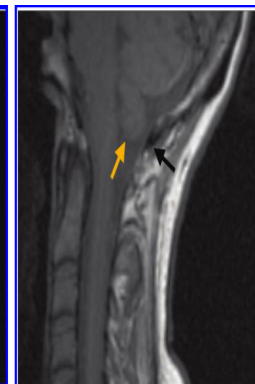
Sagittal T1-weighted magnetic resonance image of the cervical spine demonstrating normal positioning of the cerebellum (orange arrow) in relation to the foramen magnum (black arrow) in an unrelated patient. Reproduced with permission from Walk.
